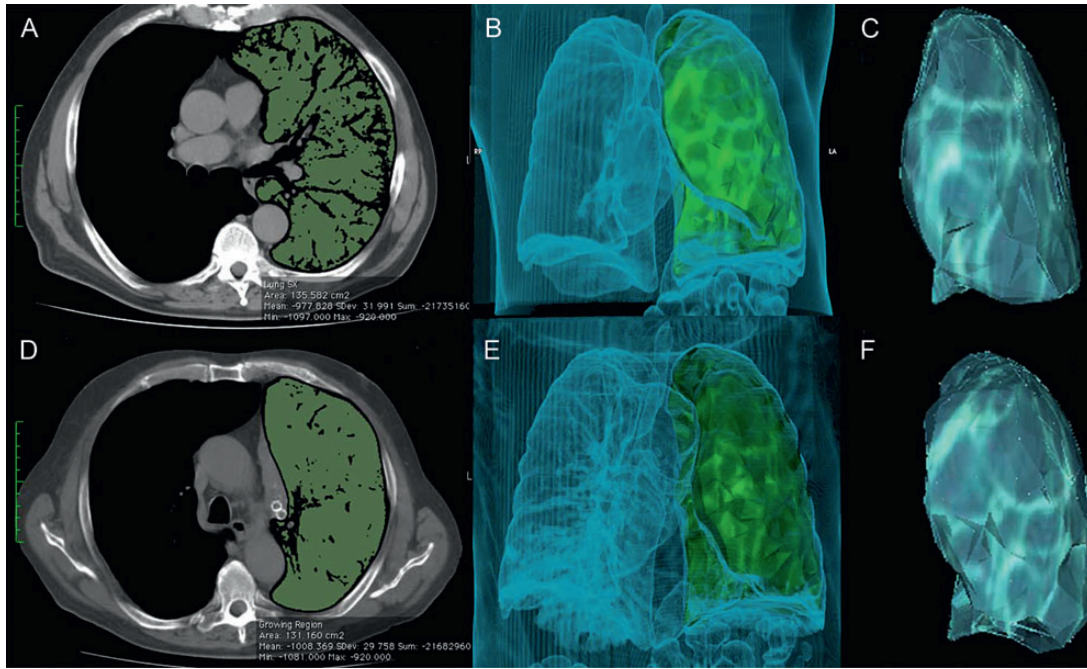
A 65-year old man presented a heterogeneous emphysema that affected mostly the left upper lobe. The entire segmentation process was shown starting from axial 2D CT scans obtained at the same level before (A) and after (D) treatment and subsequent superimposition of 2D ROI masks (qMDCT); the image segmentation process from 2D to 3D quantitative evaluation of emphysematous lung parenchyma was well represented before (B) and after (E) treatment using virtual rendered (VR) reconstructions; volumetric quantitative estimations in mm³ are visualized after applying a 3D surface mesh on previously calculated volumes before (C) and after (F) treatment.
